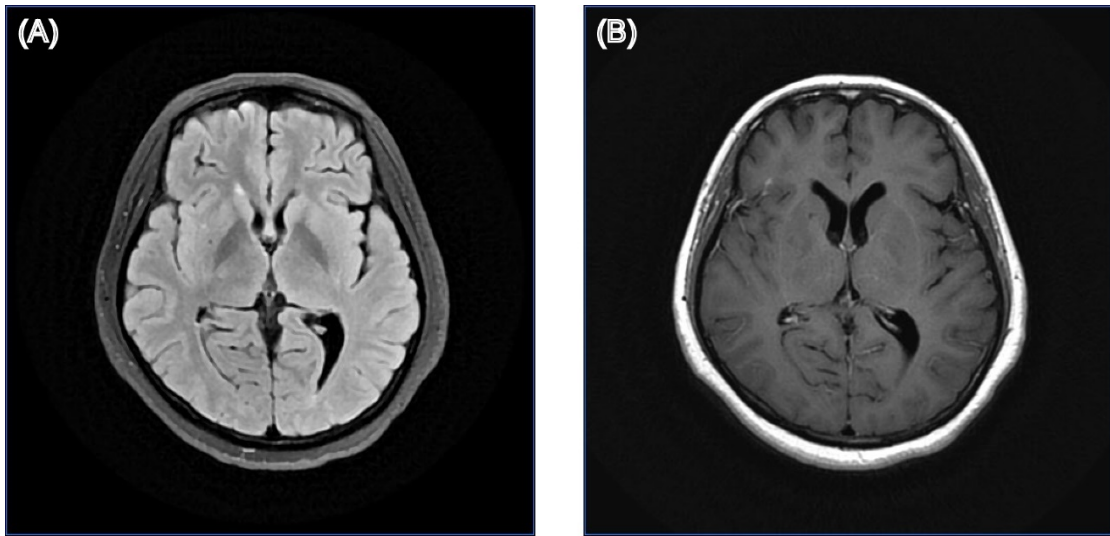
Structural brain MRI images of patient 19. (A) T2-weighted fluid-attenuated inversion recovery (T2-FLAIR) image; (B) Gadolinium-enhanced T1-weighted (Gd-T1w) image.
